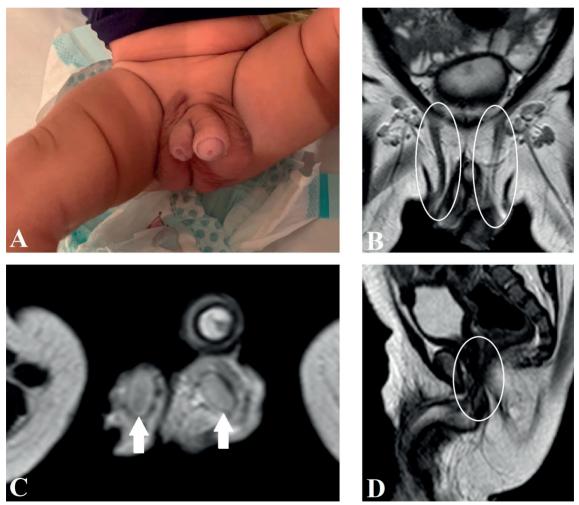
A: A visual demonstrating two penises - diphallia. B: The MRI in the coronal section in the T2 sequence showing normal spermatic cords (white circles). C:MRI in the axial section in the T2 sequence showing normal testicles (white arrows). D: MRI in the sagittal section in the T2 sequence, the rectum appears to join in the urethra - a defect of the urogenital sinus (white circle).
